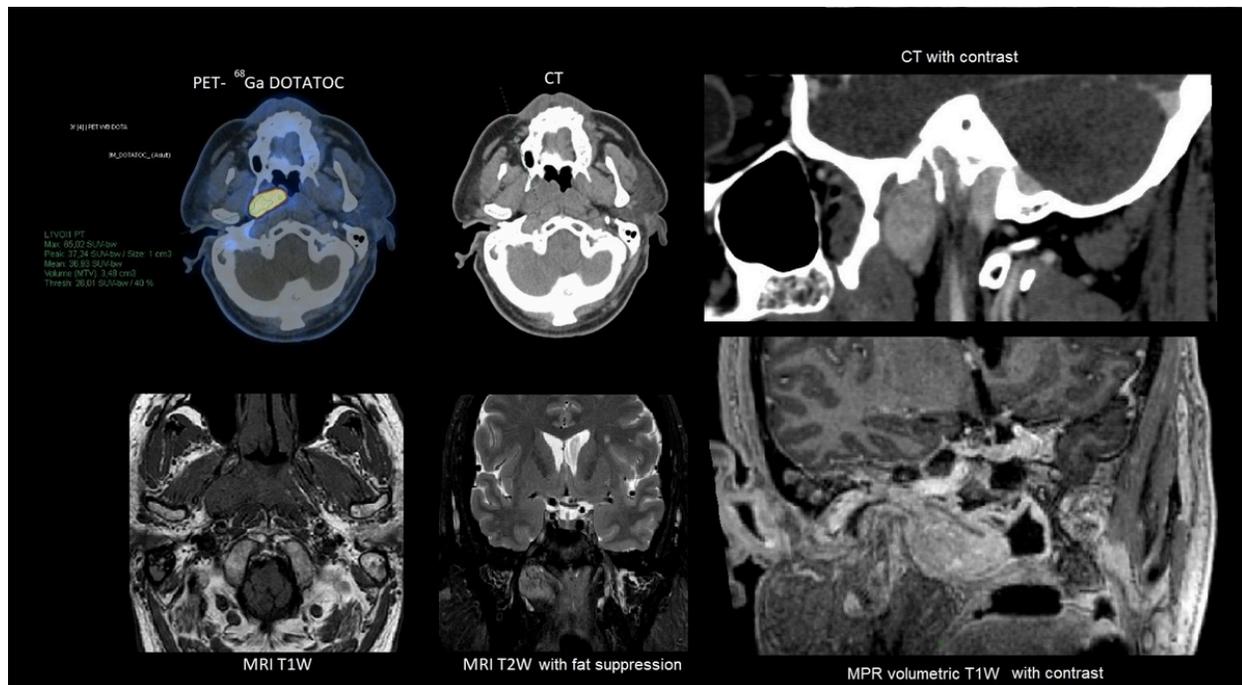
PET-68Ga-DOTATOC, CT and MRI images with MPR reconstructions in both CT and MRI with contrast that show the appearance of a jugulotympanic paraganglioma, indeed involving the jugular fossa and the middle ear with an uncommon extension to the nasopharynx through the Eustachian tube.
